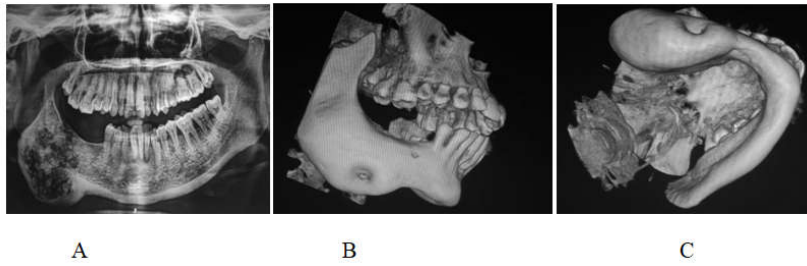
A panoramic radiograph revealed an ill-defined mixed radiopaque and radiolucent lesion of size approximately 4×5 cm, which extends from the mesial aspect of 44 to angle of the mandible
